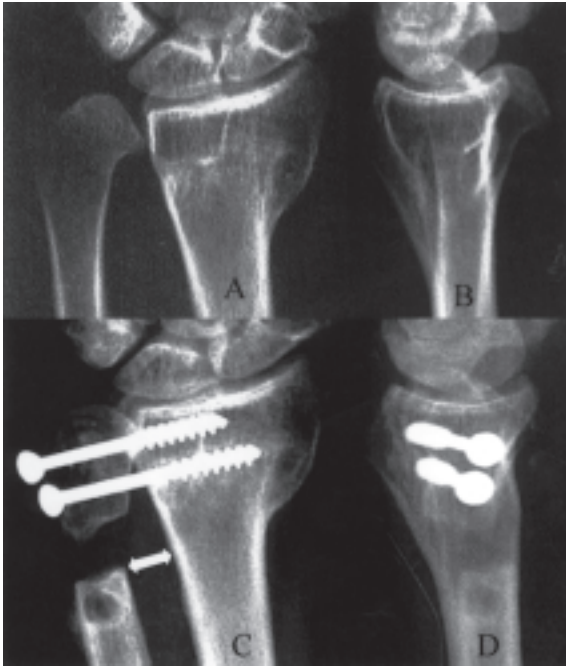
The preoperative anteroposterior (A) and lateral (B) radiographs show dislocation of the distal radioulnar joint with arthritis. The postoperative anteroposterior (C) and lateral (D) radiographs show union of arthrodesis of the distal radioulnar joint.
